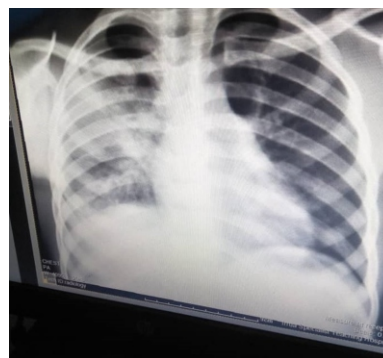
plain Chest Xray PA view showing Normal heart size, (CTR-50.7%), inhomogenous opacities with air bronchogram in keeping with consolidation involving the right upper, mid and lower lung zones with relative sparing of the apex. The left lung field appeared normal. Impression: Lobar pneumonia
